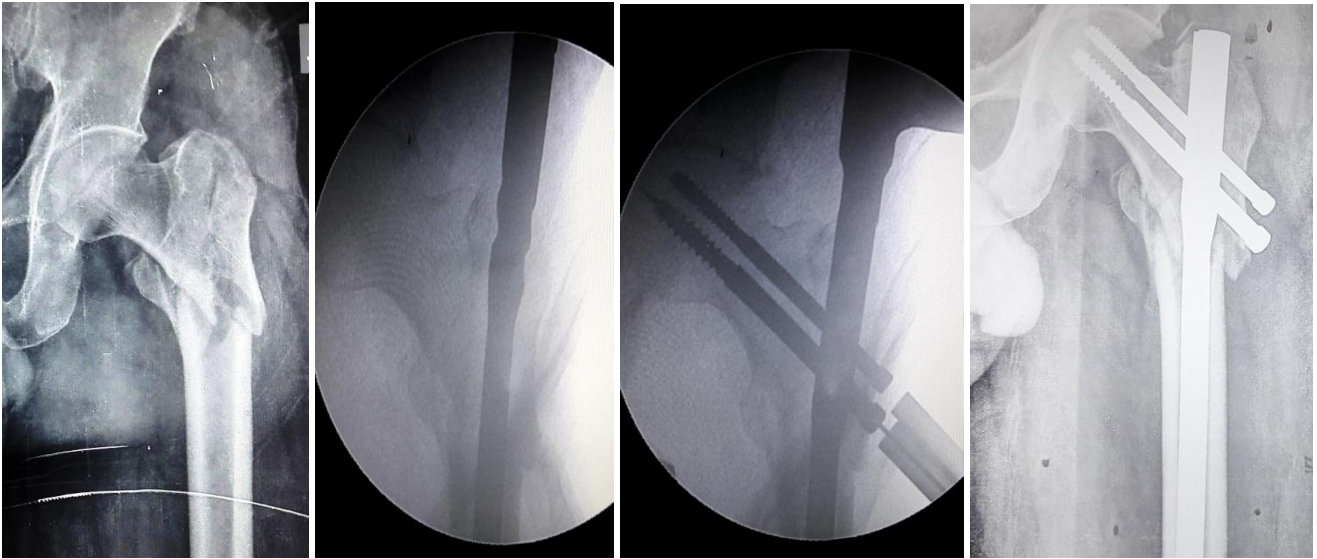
showing Preoperative, intraoperative and postoperative x-ray of PFN through greater trochanter entry showing varus deformity.
